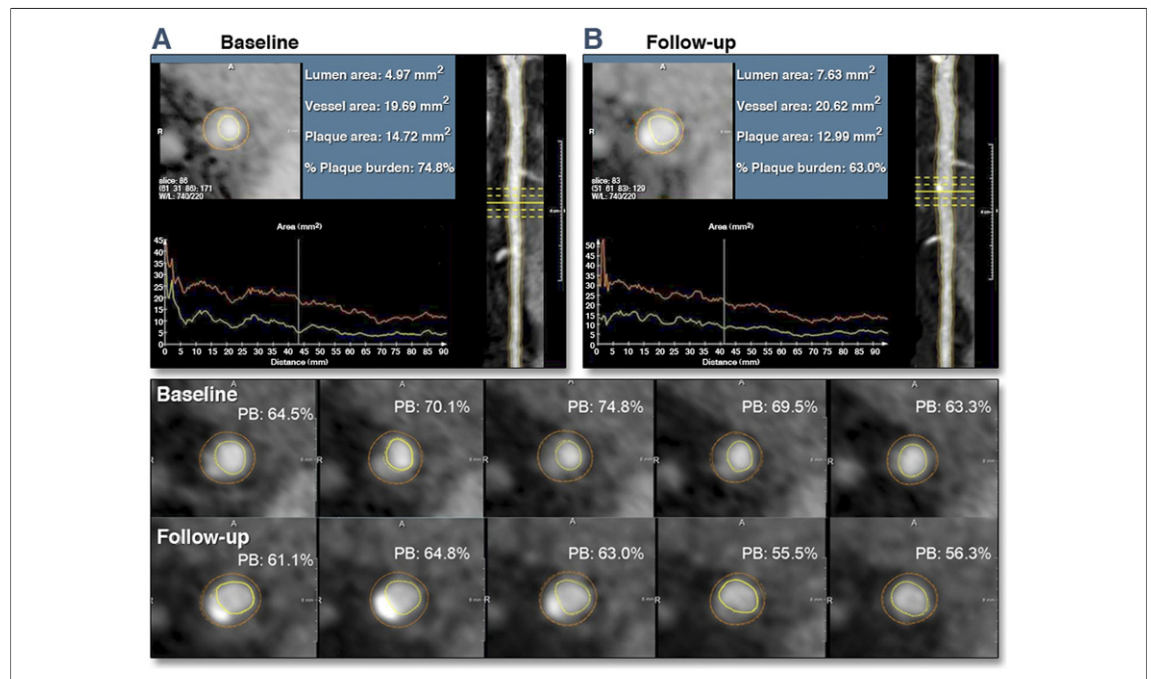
Multislice Computed Tomography Angiography Analysis
